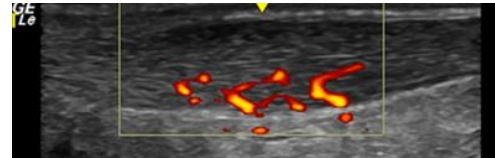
Neovascularization visualized using Power Doppler ultrasound imaging within the Achilles tendon.
